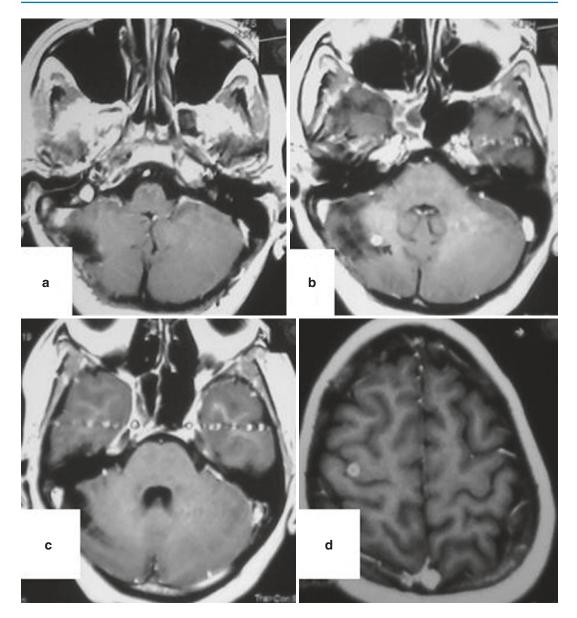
Postoperative contrast MRI of patient of Fig. 8.9; (a–d) axial sections showing postoperative state in the right cerebellum and CPA with very small lesion in the right cerebellum and right frontal lobe
